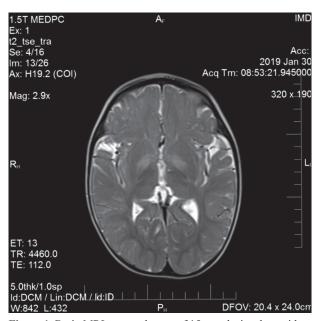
Brain MRI scan at the age of 15 months in a boy with SSADH deficiency revealing incomplete myelination and signal hyperintensity in globi pallidi
